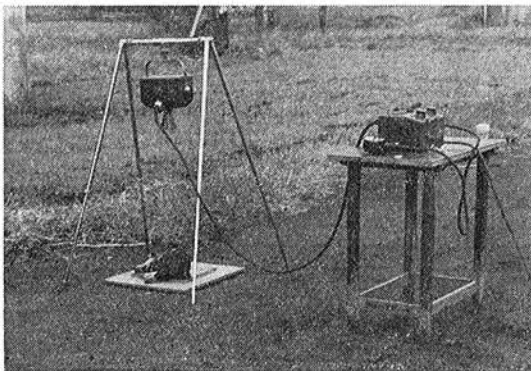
X-ray photography under way in field
